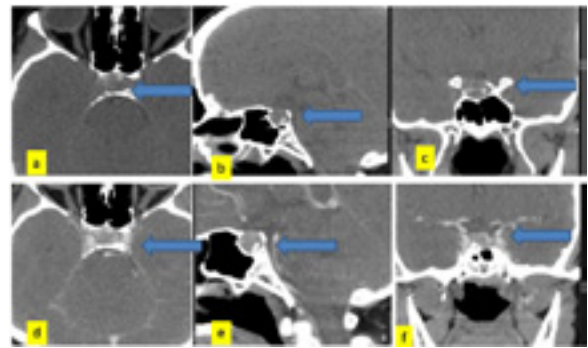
Preoperative CT scan patient number. a: axial, b: sagittal, c: coronal, non-enhanced, d: axial, e: sagittal, f: coronal enhanced CT scan of pituitary gland showing mild widened sella by well-defined pituitary macroadenoma
